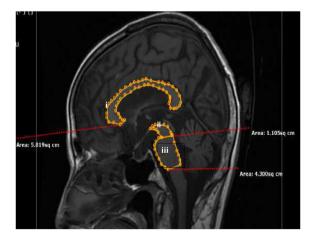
T1-weighted sagittal MRI image showing surface area measurements of the corpus callosum (i), midbrain (ii), and pons (iii).
